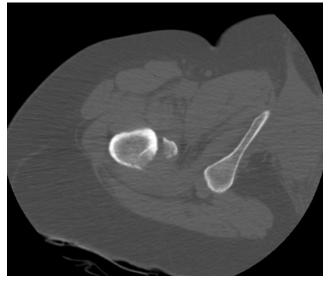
Axial computed tomography shows fracture on presentation.
